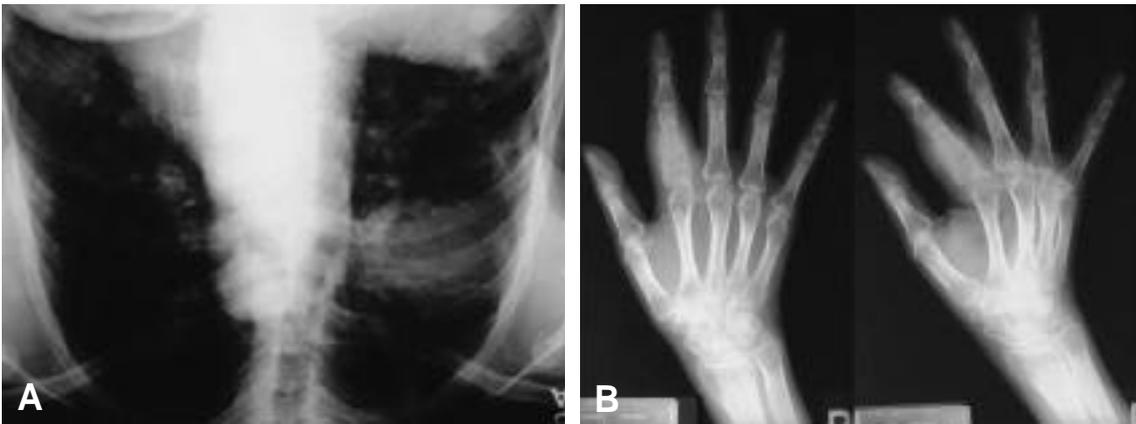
A: Simple Roentgenogram of chest PA shows multiple radiopaque mass-like lesions of right lung.
